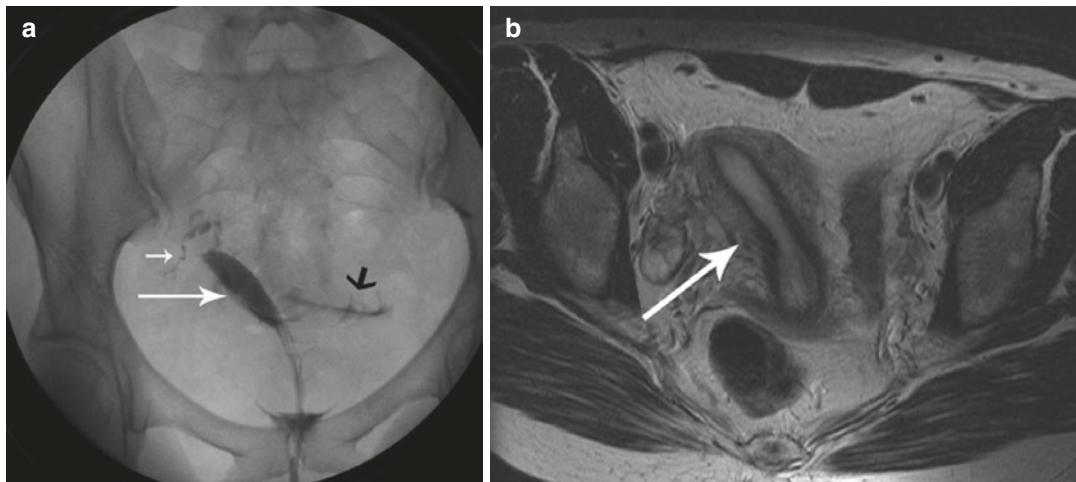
(a) Hysterosonogram in a 28-year-old woman undergoing an infertility workup shows a right unicornuate uterus without a rudimentary horn. The spillage (black arrows) of injected contrast is from the single patent right
